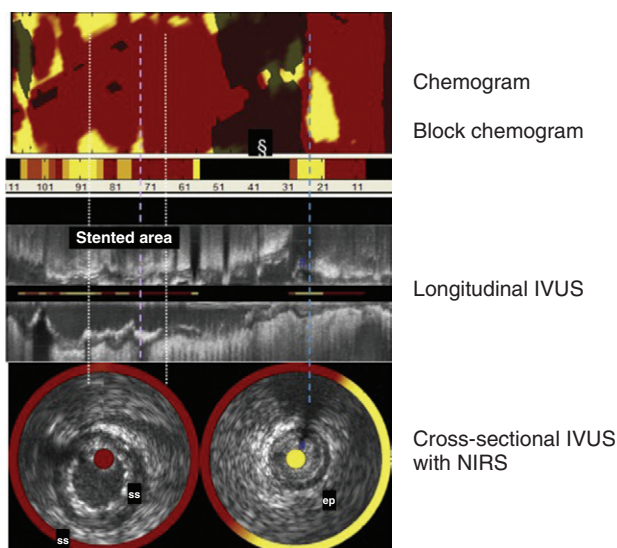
Near-infrared spectroscopy (NIRS) catheter combined with intravascular ultrasound (IVUS). (Courtesy of Dr. Patrick Serruys, Rotterdam.)
